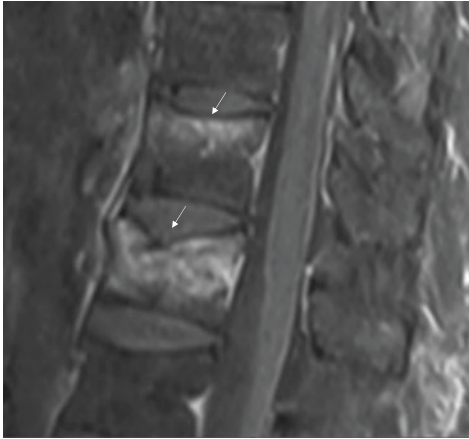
Sagittal fat-saturated post-gadolinium T1-weighted image demonstrates intraosseous enhancement in association with benign T11 and T12 wedge compression fractures (white arrows). The posterior vertebral cortices are smooth, and there is no abnormal enhancement in the prevertebral or epidural space
